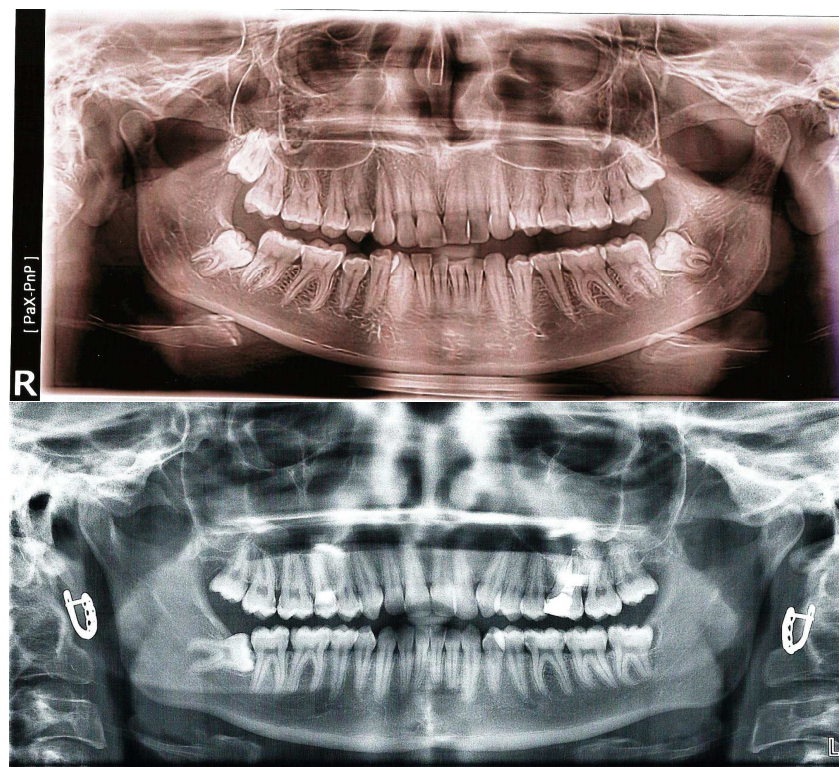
A. Permanent dental occlusion in patients aged 21 years with developmental disorders 18, 28, 38, 48. On the upper and lower jaws there are wisdom teeth that are in a retained state (orthopantomogram). B. Dystopia 48: medial position of the affected 48 in a patient aged 35 years (orthopantomogram).
